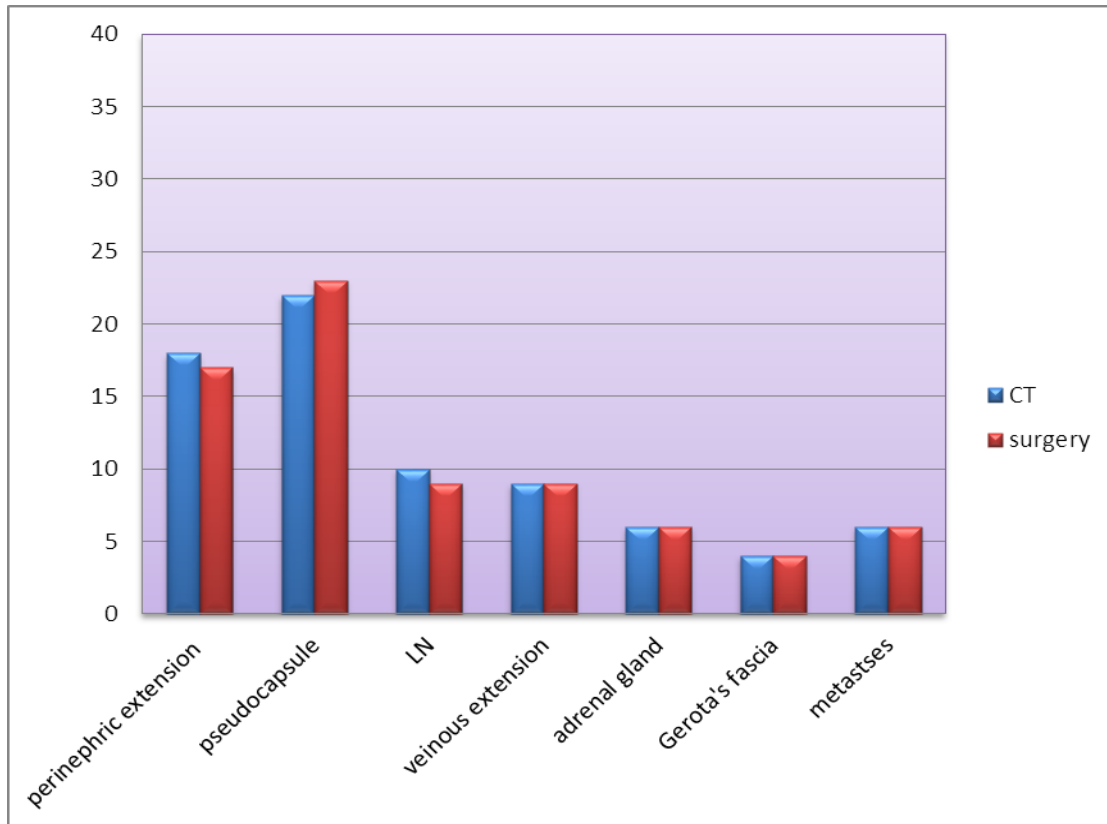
histogram shows results of CT and surgery
